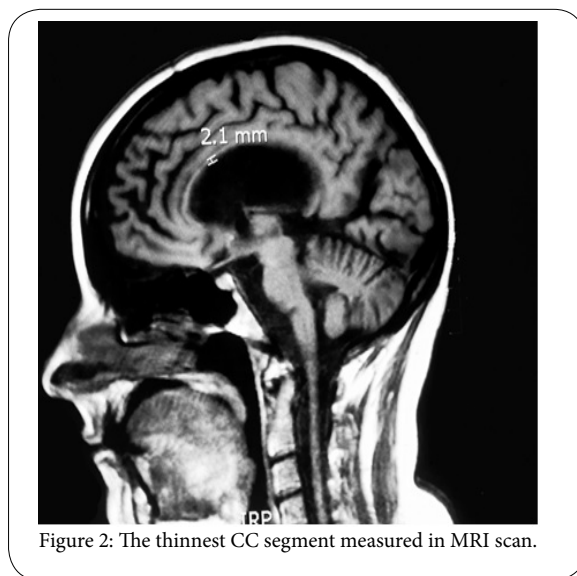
The thinnest CC segment measured in MRI scan.
